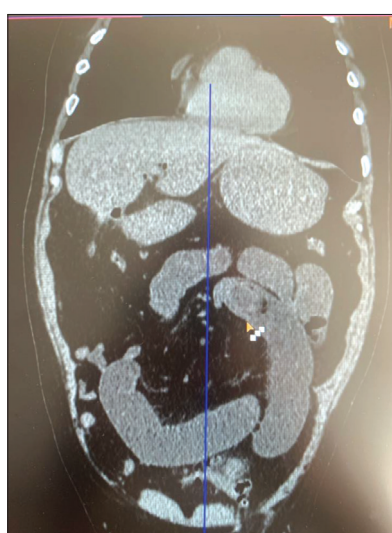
Magnetic resonance imaging – gallstone in the ileum
